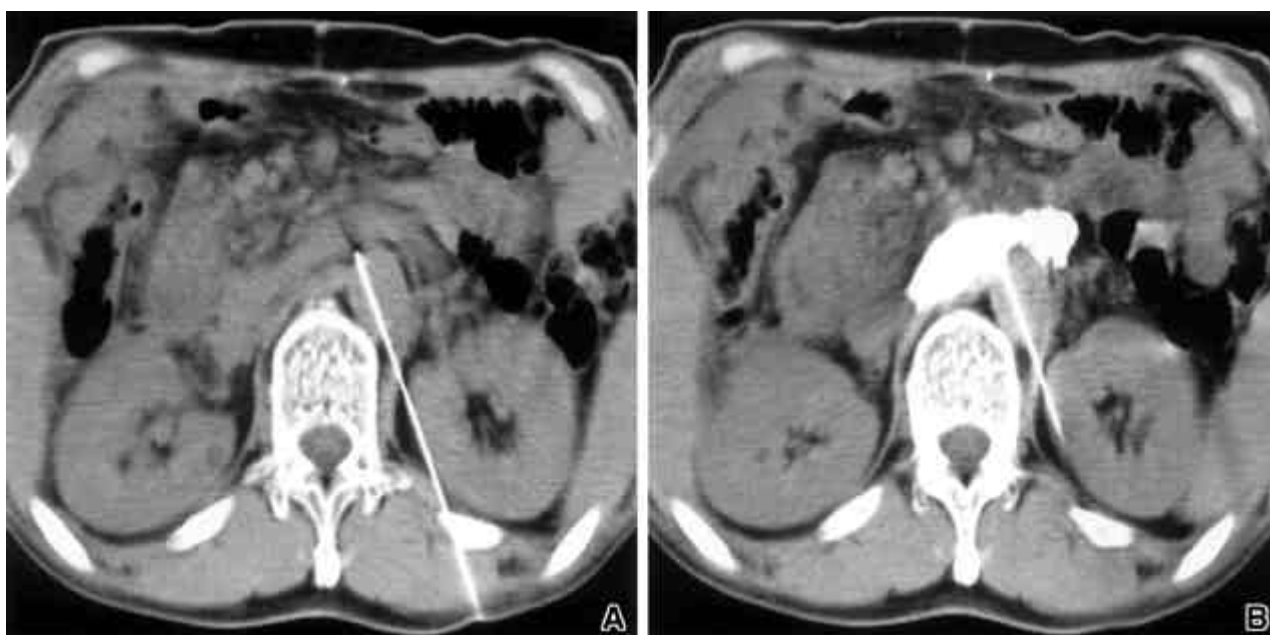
Single-needle transaortic technique. Axial CT scan at the L1-vertebral level, the patient lying prone, shows placement of needle transaortically into the preaortic space (A) and pre-aortic spread of contrast agent (B).
